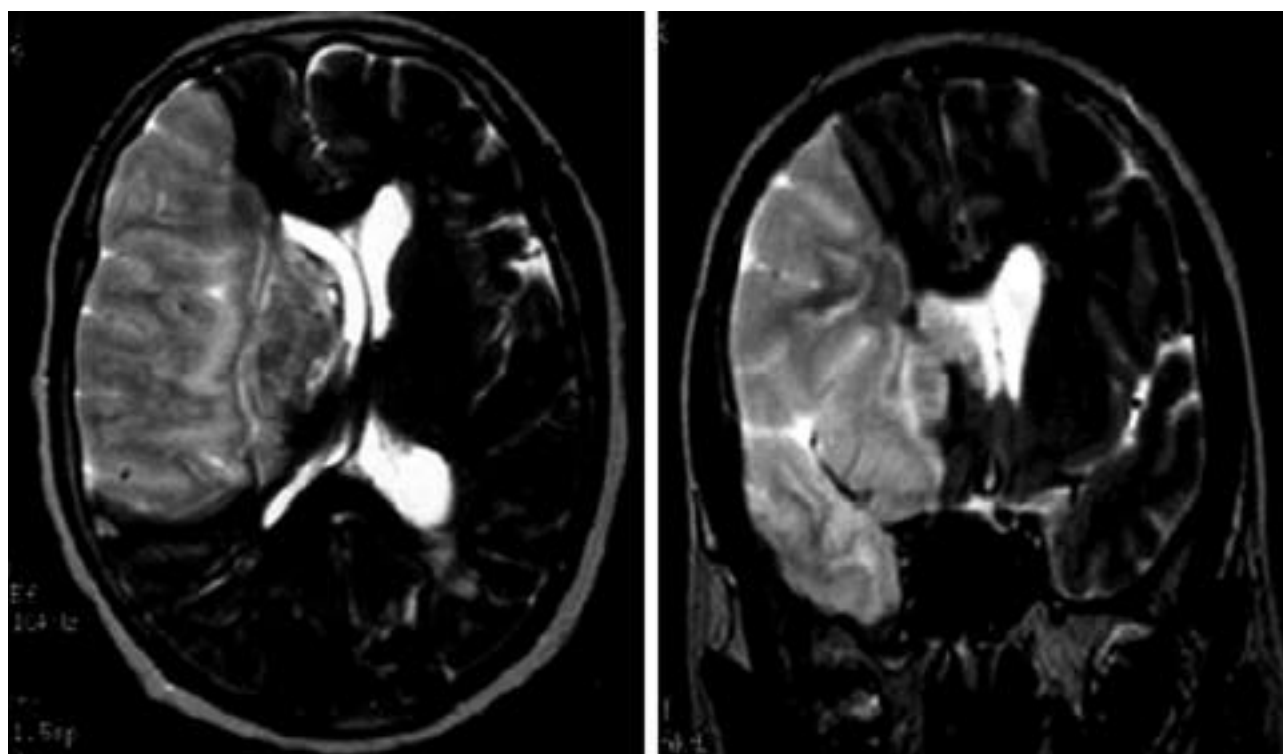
Brain MRI of acute stage of right middle cerebral artery infarction.
